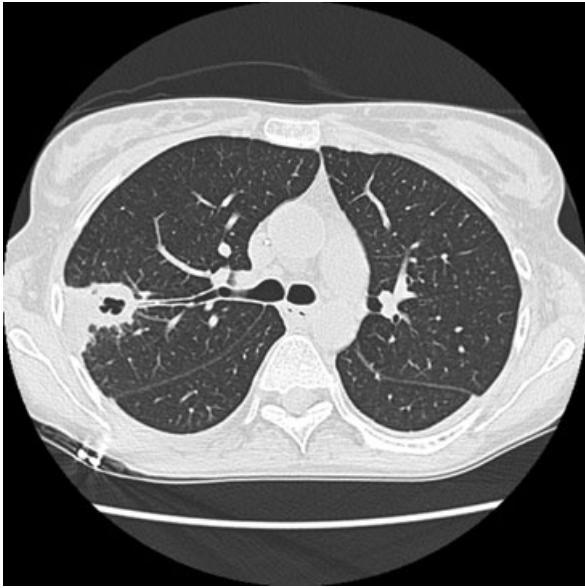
CT scan of the thorax with focal lesions indicative of invasive pulmonary aspergillosis in the right hemithorax.
